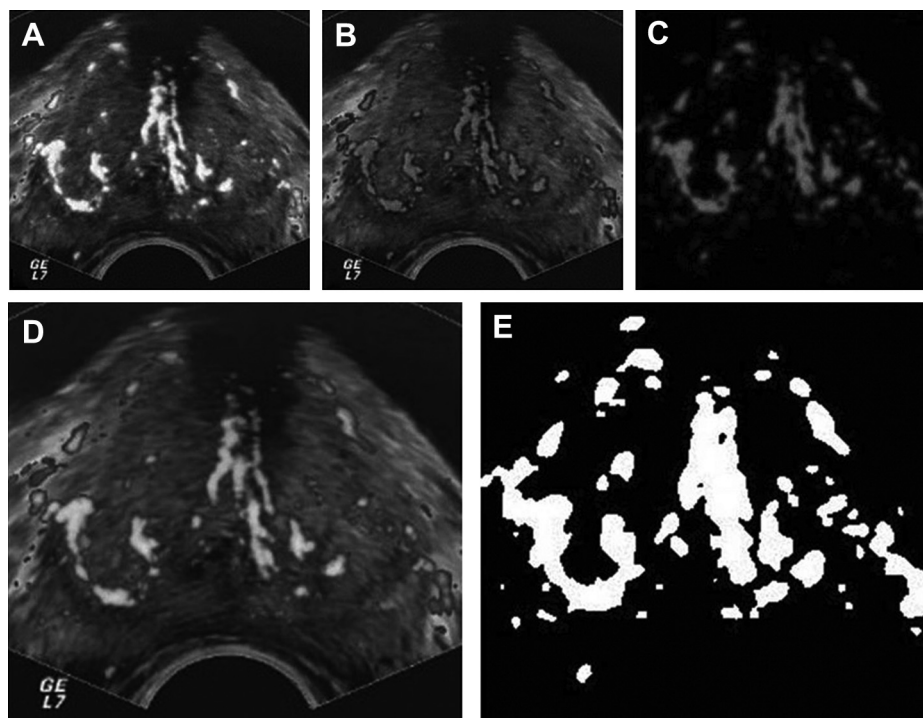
(A–C) The differences between the red, blue, and both channels respectively, in the digital image analysis. (D,E) The original power Doppler image and an image showing the vascularization areas obtained after analysis.
